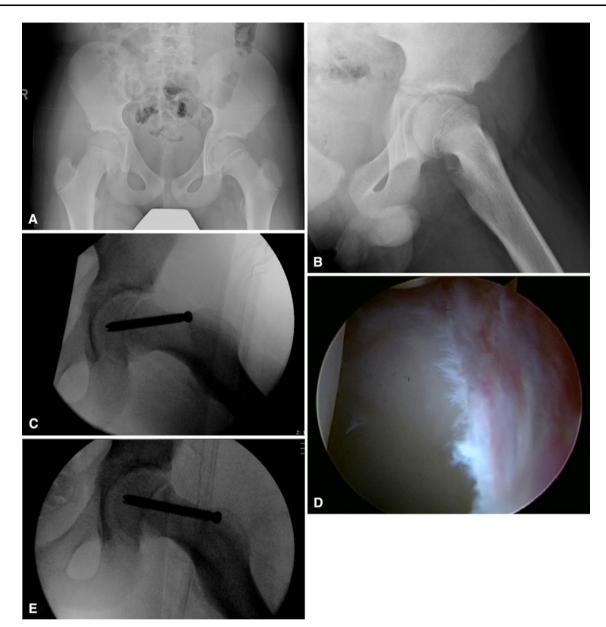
E (A) Irregularity of the left femoral physis is evident on the AP pelvis radiograph of Patient 4. (B) The frog leg lateral image demonstrates a slip angle of 31° and an alpha angle of 85° . (C) An intraoperative fluoroscopic 45° Dunn lateral view shows prominence
